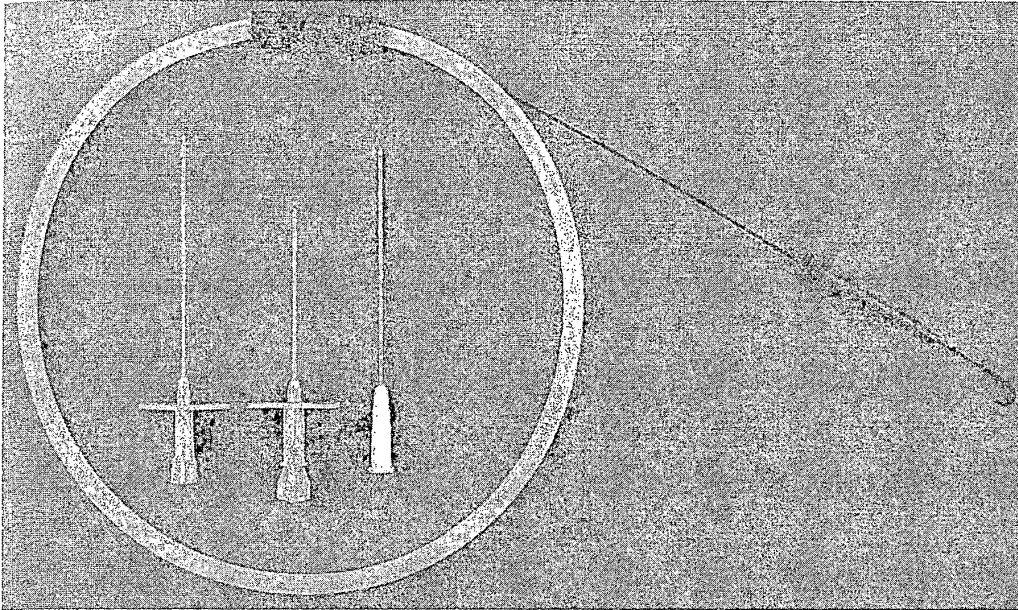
Percutaneous needles and guidewire. Top panel shows a Seldinger needle (left) with its sharp solid obturator in place, a Potts-Cournand needle (center), which differs in the fact that its obturator is hollow and therefore allows the operator to see blood flashback as the artery is punctured, and an 18-gauge thin-wall needle (right) used for internal jugular vein puncture and now frequently also for arterial entry. These percutaneous needles are surrounded by an 0.038-inch, 145-cm J guidewire. Bottom panel: A Doppler-guided Smart Needle.
